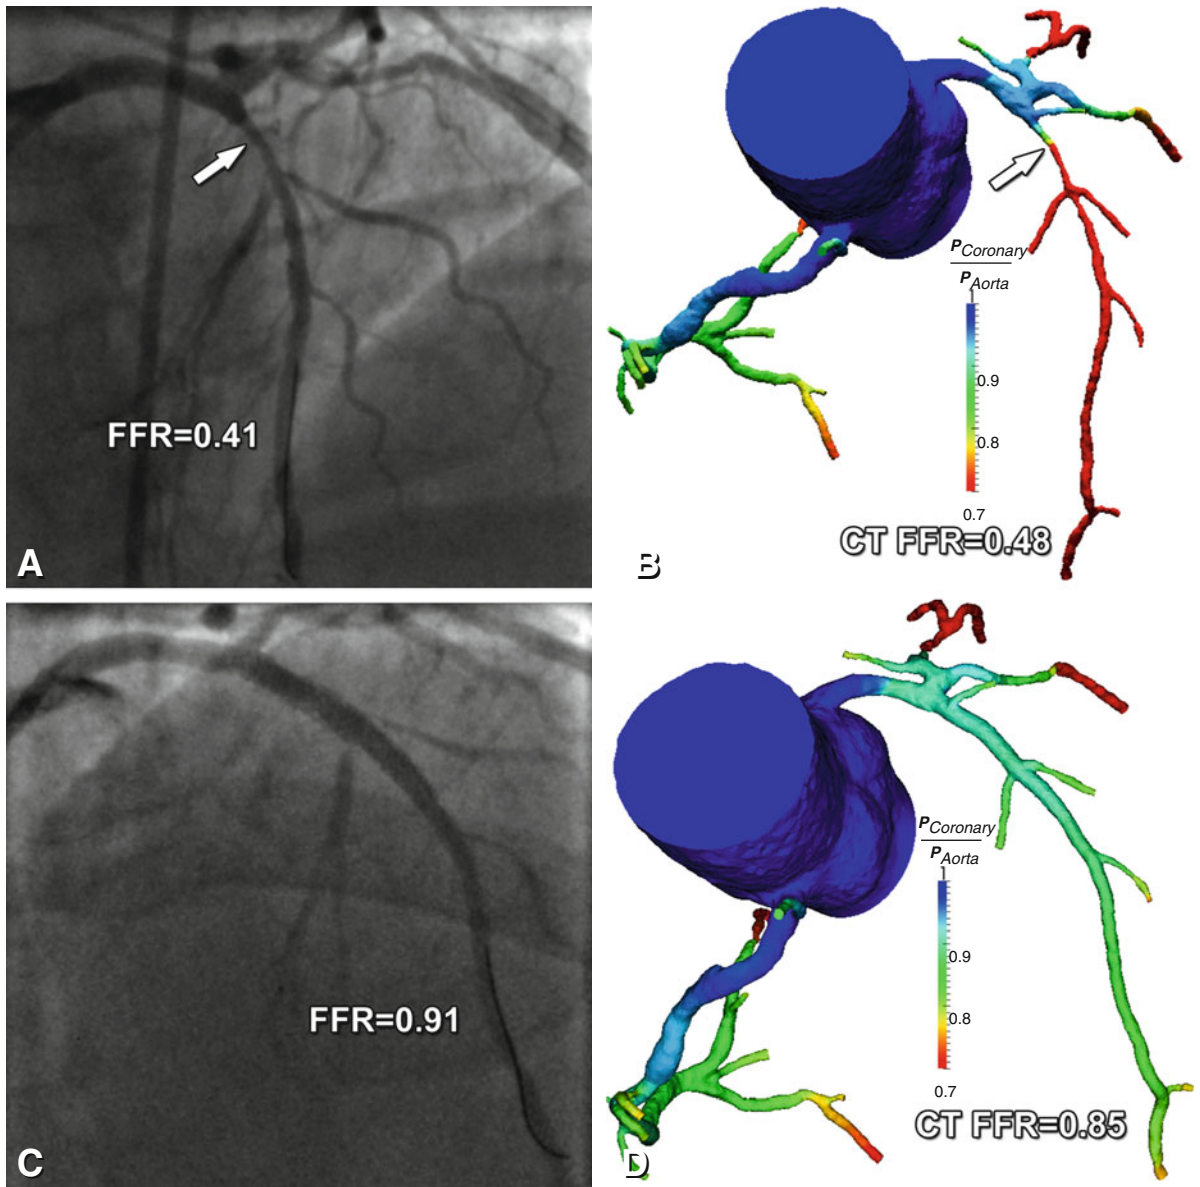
A case example of predictive modeling for percutaneous coronary intervention planning. Angiography demonstrated a significant stenosis in the left anterior descending artery (arrow in Panel A). The pretreatment model revealed stenosis with a CT FFR 0.48 (arrow in Panel B), which was in good agreement with invasive FFR (Panel A). The actual post-stenting FFR of 0.91 (Panel C) was well predicted using modeling based on CTA (Panel D)
